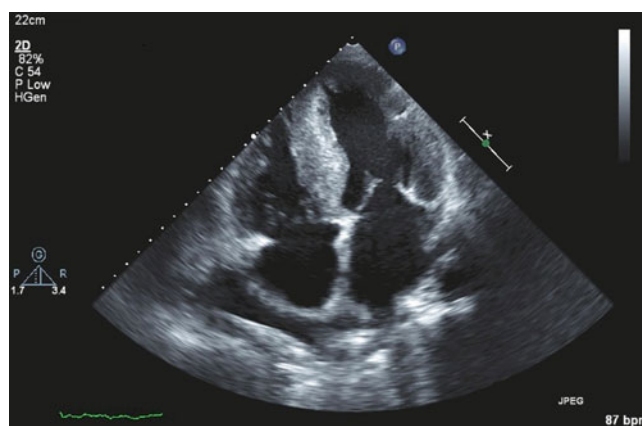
Two dimensional echocardiogram of a patient with Amyloid cardiomyopathy. Note the thickened RV wall, pericardial effusion and thickened valve leaflets
